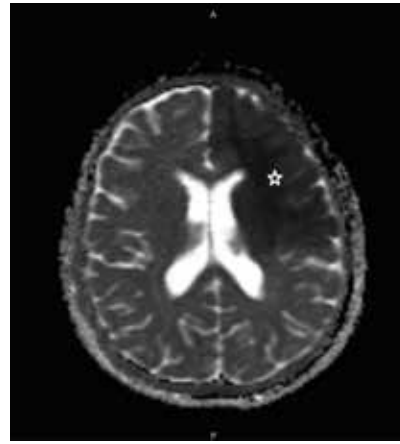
The cranial MRI of the patient revealing large ischemic lesions on the perfusion area of the left middle cerebral artery and left anterior cerebral artery without hemorrhage (white star).
